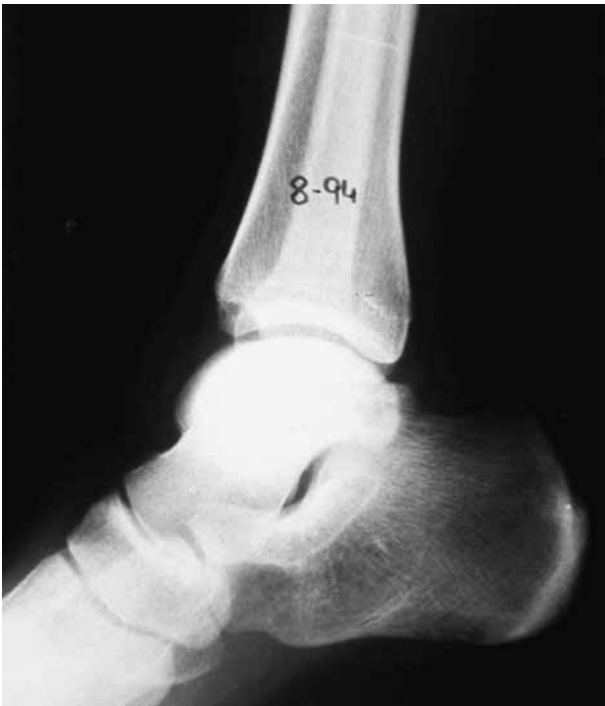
Lateral radiograph suggesting osteochondritis of the talus.
